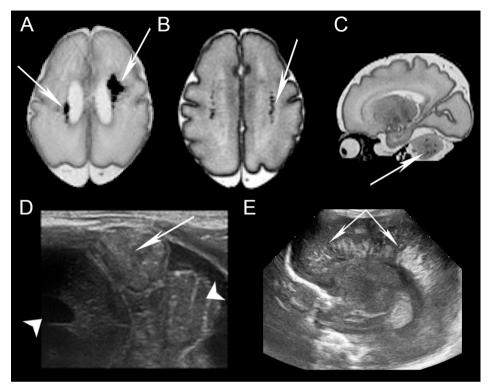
Examples of brain injury patterns on MRI (A-C) and CUS (D-E): A: bilateral periventricular hemorrhagic infarction on axial T2-weighted scan, note the ventricular dilatation caused by intraventricular hemorrhage; B: punctate white matter lesions on axial T2-weighted scan; C: multiple folial cerebellar hemorrhages on sagittal T2-weighted scan; D: cerebral sinovenous thrombosis in transverse sinus on cranial ultrasound, assessed through mastoid fontanel, note the large mass (arrow) between the lateral ventricle (left arrowhead) and cerebellum (right arrowhead), and E: periventricular leukomalacia on parasagittal cranial ultrasound, assessed through the anterior fontanel.
